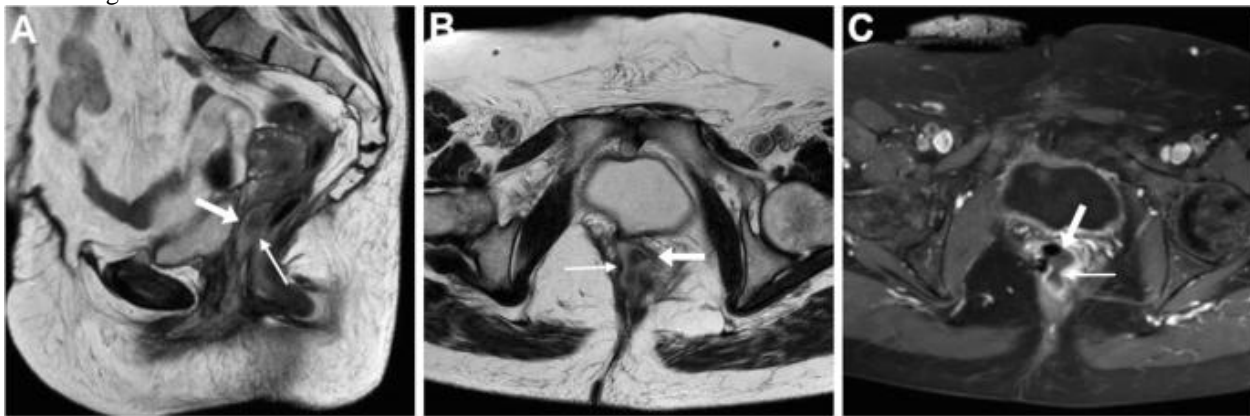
Pelvic and Rectovaginal Fistula on CT, MRI, and MDCT
